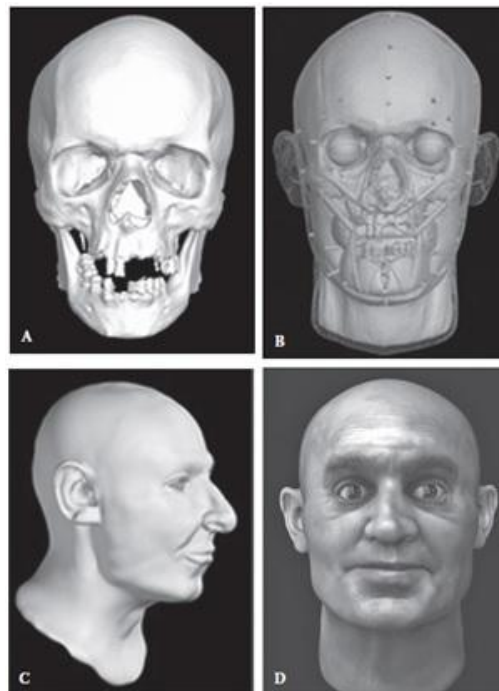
Computerized three-dimensional facial reconstruction. A digital model of the skull is produced from CT or laser scan data (A) and the facial musculature attached using three-dimensional modeling software (B). The facial reconstruction can be visualized as a "virtual" clay head (C) or skin, hair, and eye textures and colors can be added to create a more realistic three-dimensional model (D)²¹².
